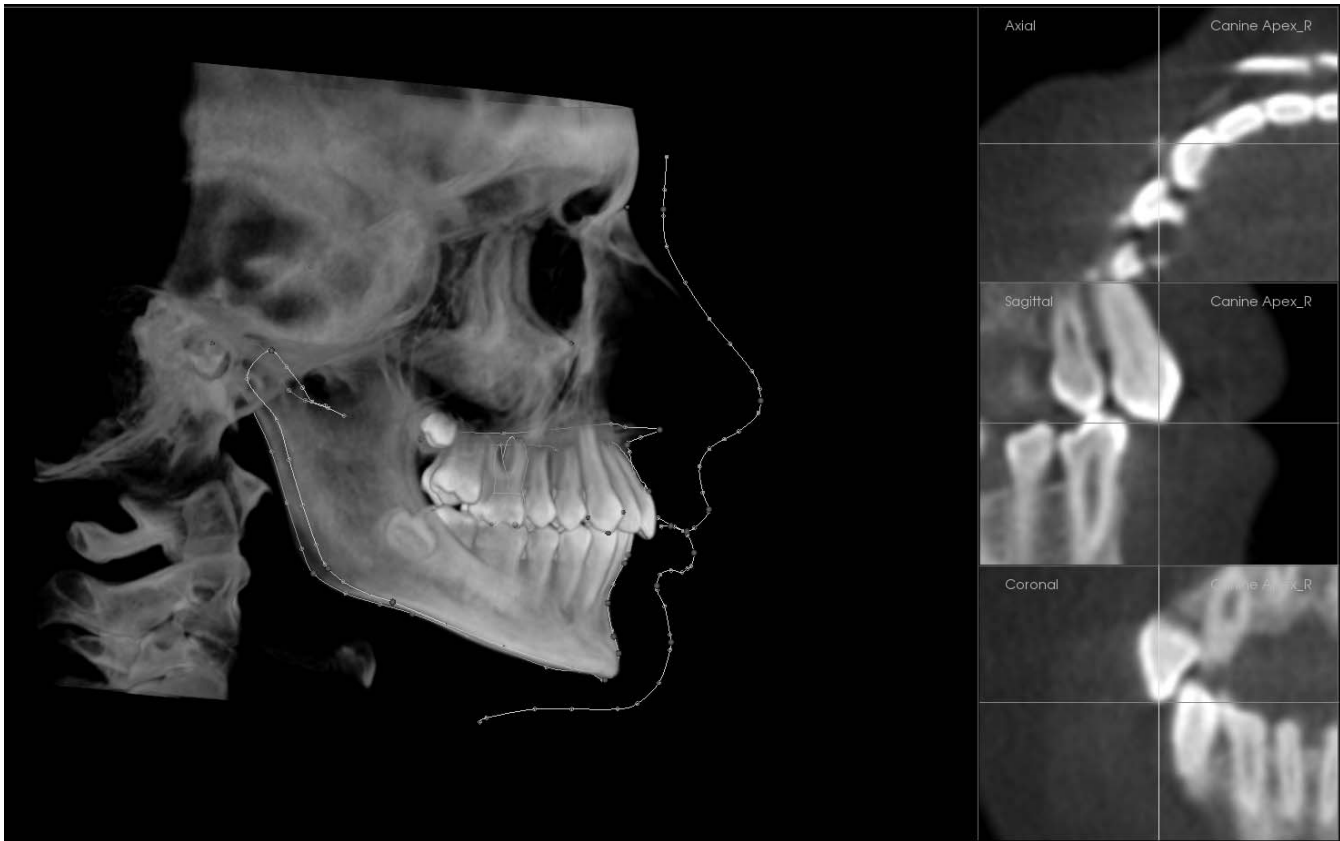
Identification of landmarks in CBCT.
